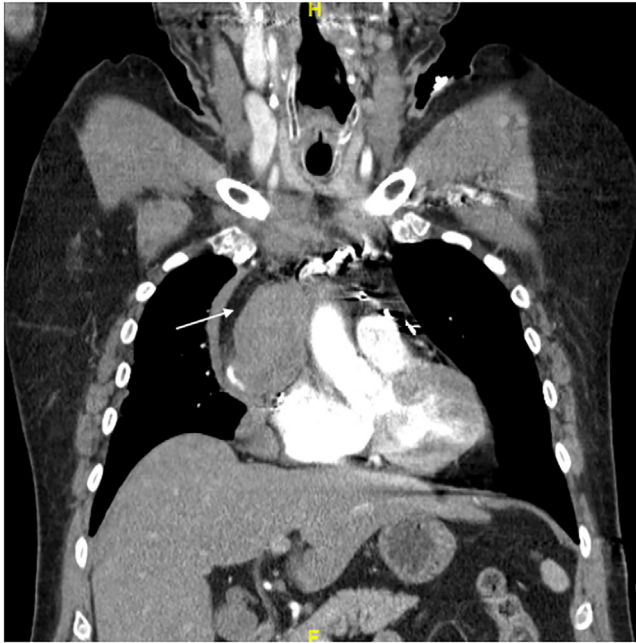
Contrast-enhanced computed tomographic scanning in the coronal plane showed a 6 × 8 × 4 cm moderate sized mediastinal hematoma at the right superolateral aspect adjacent to the ascending aorta and anterior to the superior vena cava (arrow). P = posterior
